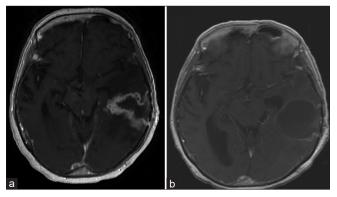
(a) Six-week follow-up contrast-enhanced axial T1-weighted MRI showing disease progression with worsening edema and mass effect. (b) One-week postoperative redo craniotomy T1-weighted contrast-enhanced T1 axial MRI showing worsening edema with a new cystic collection with mass effect and developing communicating hydrocephalus.
